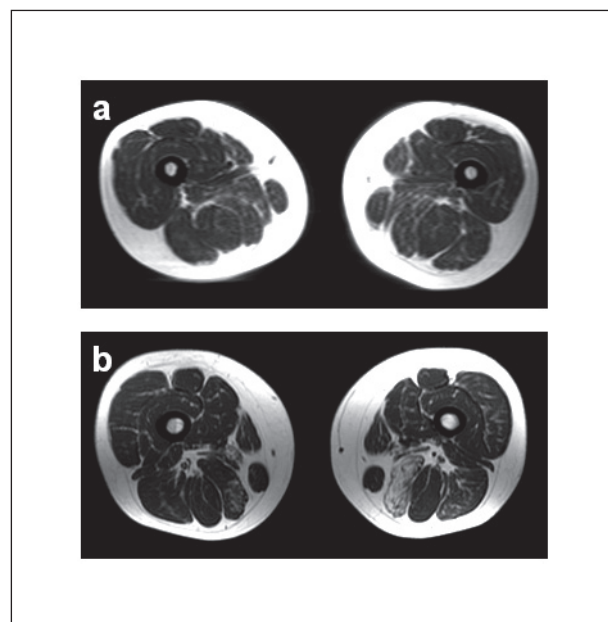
Magnetic resonance imaging (MRI, T1 fat suppressed) of the upper legs of the patient at 42 years old, with very mild asymmetric fatty replacement in the posterior compartment, accentuated in the left semimembranosus muscle (a). Further progression at follow-up after one year (b).
